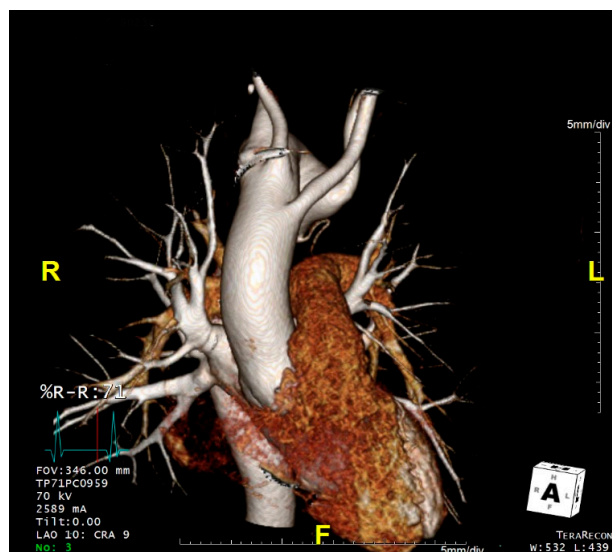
CTA – anterior view.
